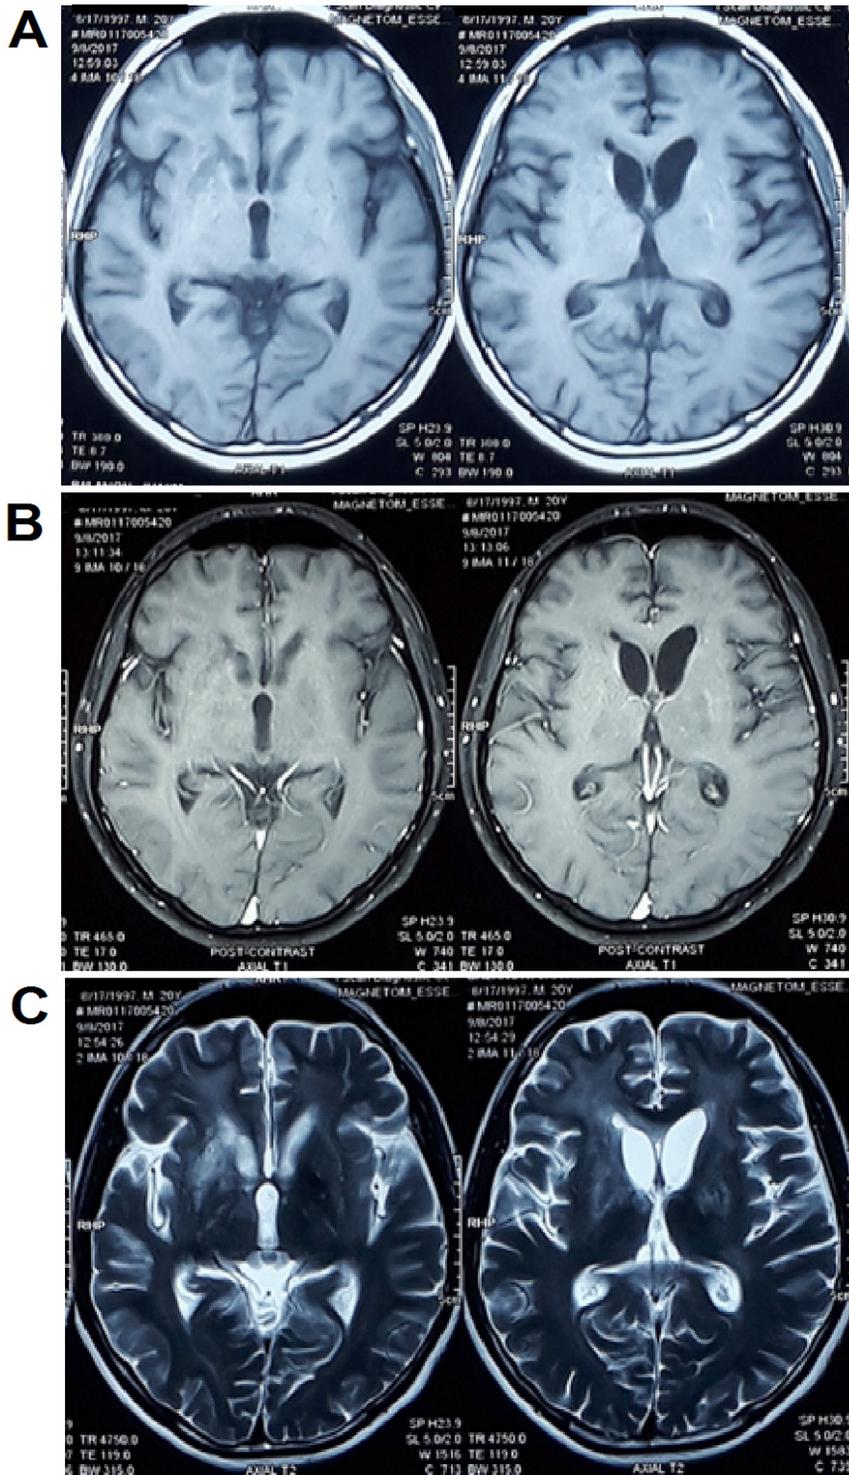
T1(A) and T1 post-contrast(B) cranial MRI.* There is reduction in size of the contrast-enhancing nodule in the right basal ganglia with smaller contrast-enhancing focus measuring 0.4 x 0.4 cm (previously 0.8 x 0.8cm). The contrast-enhancing nodule in the head of the caudate nucleus is no longer appreciated. There is partial resolution of the bilateral vasogenic edema involving bilateral frontal and basal ganglia areas with minimal residual in the white matter as seen in the T2 sequence (C).
